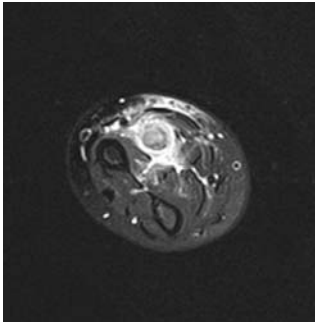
Axial T2 MRI images through demonstrating hyperintense signal of a rounded lesion surrounding the median nerve and lying adjacent to the flexor pollicis longus and flexor carpi radialis muscles.
